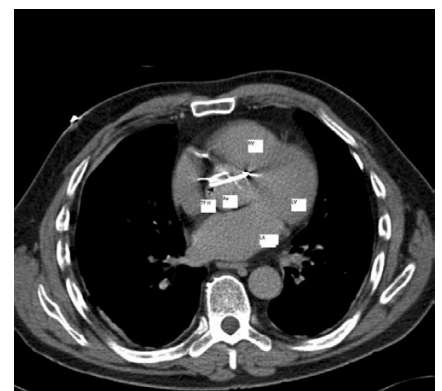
Computed tomography thorax shows TPW crossing ascending Ao into LV. Dark arrow points to temporary pacing wire. LA, left atrium, RV, right ventricle; TPW, temporary pacing wire; Ao, aorta; LV, left ventricle.
